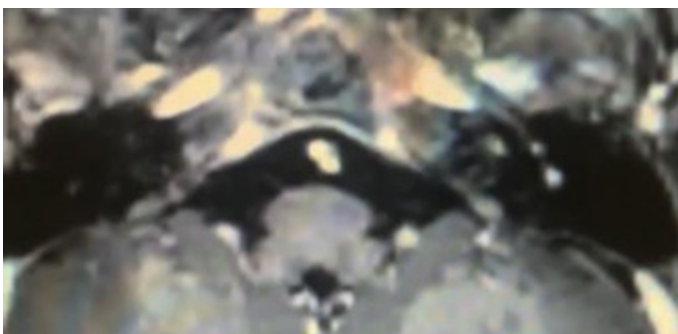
T1-MRI shows mild gadolinium enhancement at the GG level on the left side. GG, geniculate ganglion; MRI, magnetic resonance imaging.
